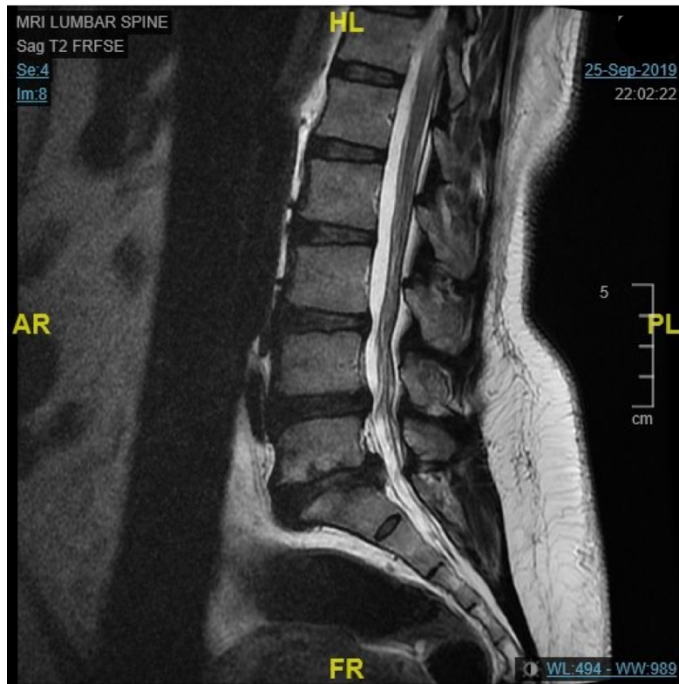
1. Original design of the MRI Lumbar spine image
